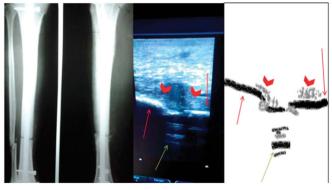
A 32-year-old patient with delayed union radiograph at 20-weeks postoperatively showing delayed union of tibia fracture; ultrasonography (original and animation) at 16 weeks postoperatively showing bone cortex (red arrows), nail (green arrow), and periosteal soft callus (red arrow heads), predicting delayed union of fracture.
